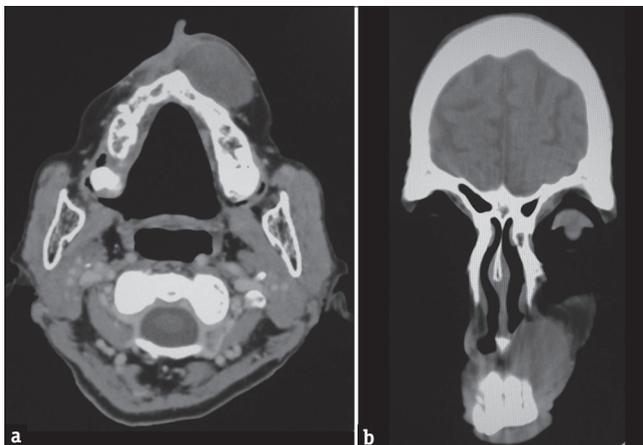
(a) Axial computed tomography scan image showing hypodense area in left premaxillary region. (b) Coronal computed tomography scan image showing hypodense area in left premaxillary region
